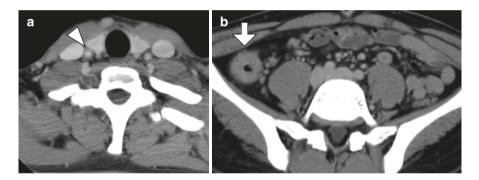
Enhanced computed tomography (CT) images in a patient with Takayasu arteritis complicated by Crohn's disease. (a) Wall thickness of the right carotid artery is shown (arrowhead). (b) Ascending colon shows wall thickness due to inflammation from Crohn's disease (arrow)
